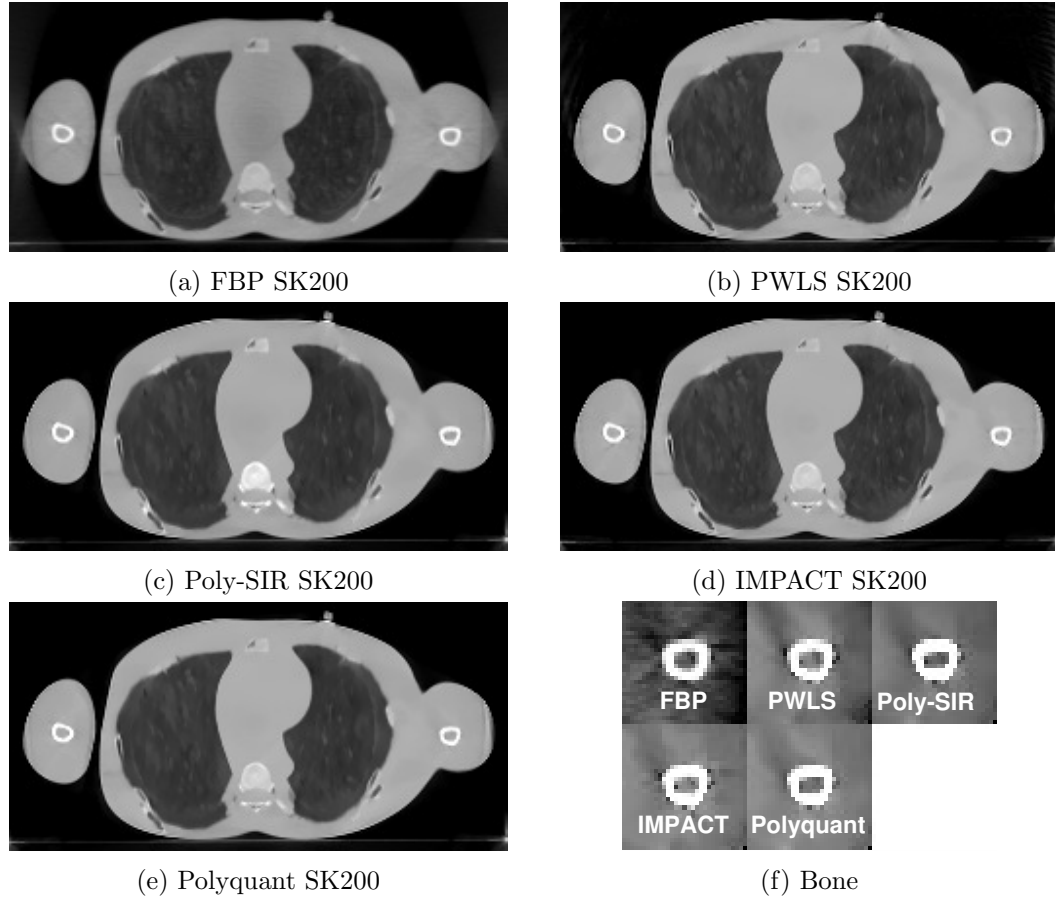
Results from mass density reconstruction from real CBCT data, where each is shown with display window  $[0,1.5]$ .
